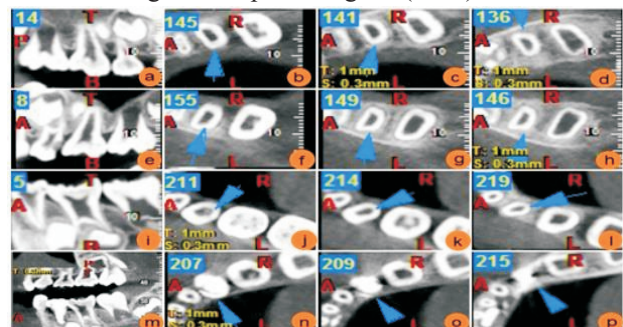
Different CBCT views at different levels.
